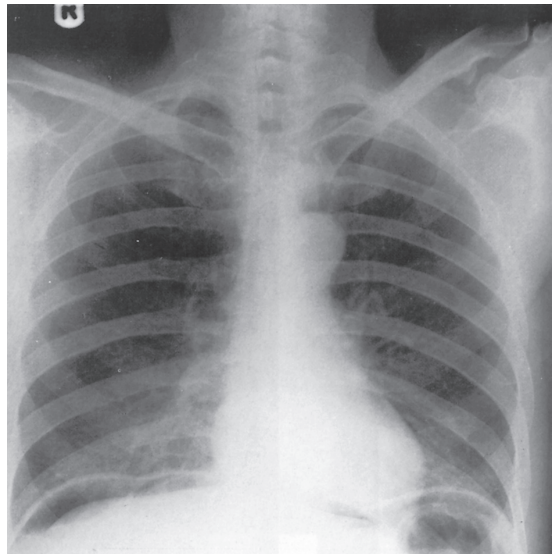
X-ray of the chest and upper abdomen.
